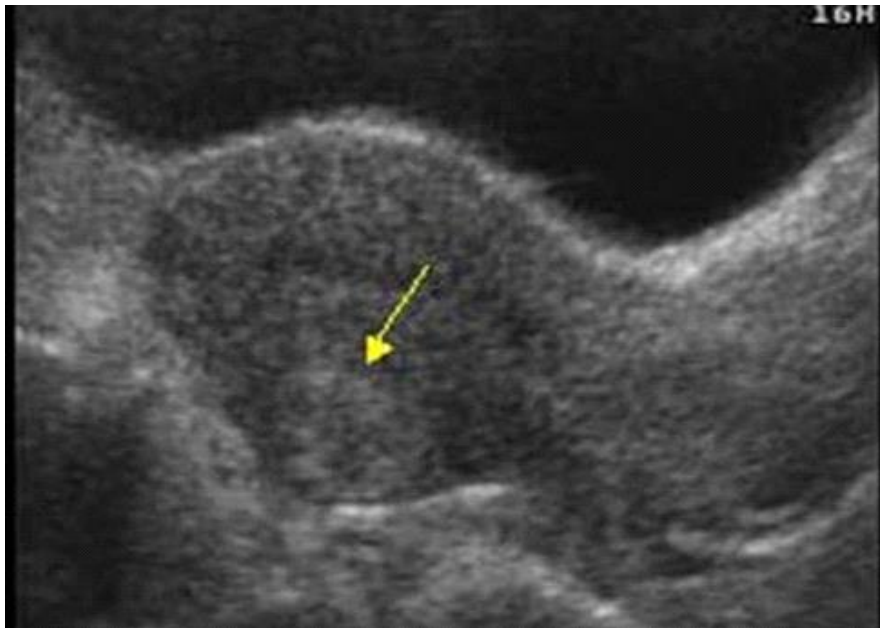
Shows Transabdominal ultrasound image of uterine fibroid of 38 years patient
